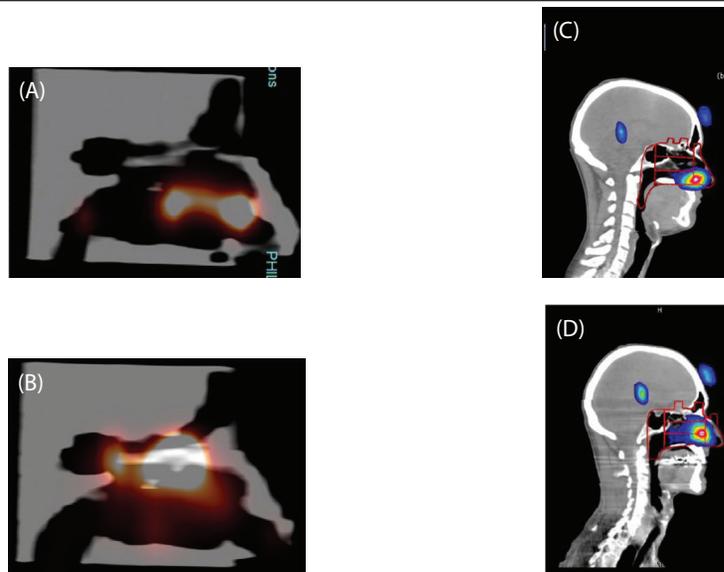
Examples of *in vitro* (left, (A) liquid, (B) powder) and *in vivo* (right, (C) liquid, (D) powder) scintigraphy deposition images.
